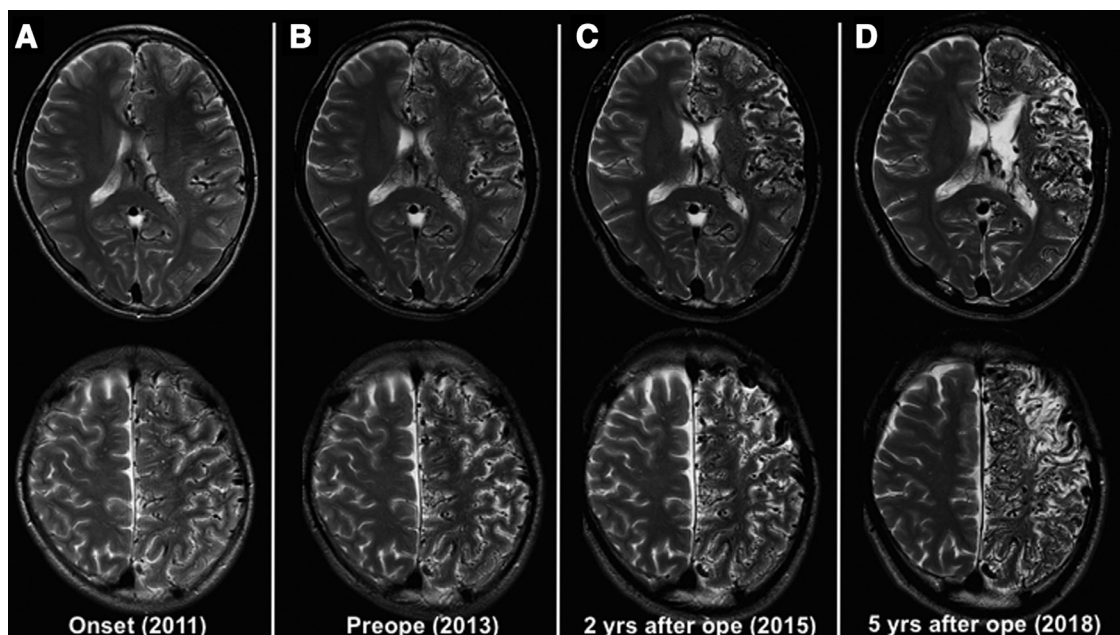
Axial T2-weighted images at onset in 2011 (A); at preoperative state in 2013 (B); 2 years after indirect revascularization in 2015 (C); 5 years after indirect revascularization in 2018 (D). Progressive vascular proliferation and brain atrophy were found.
